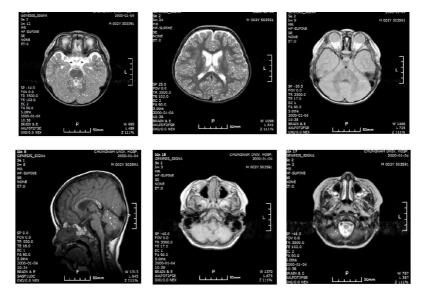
Brain MRI T2 weighted axial view case 1 showed diffuse cerebral cortical atrophy in both fronto-temporal lobe.
